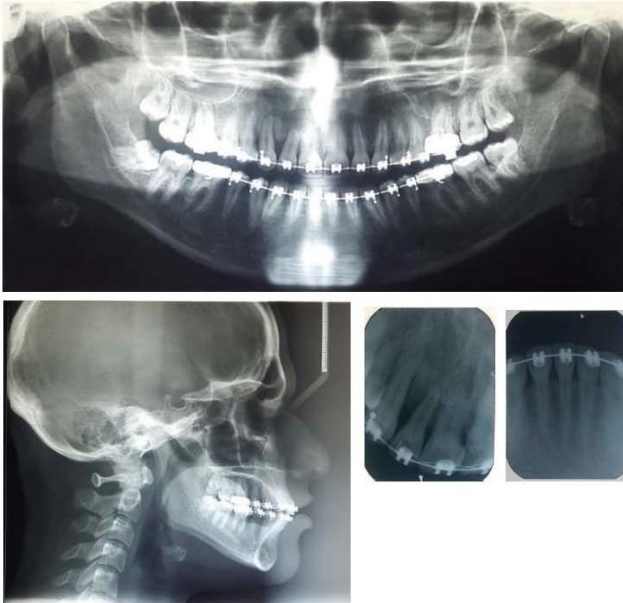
radiographic records taken upon approaching the end of treatment
